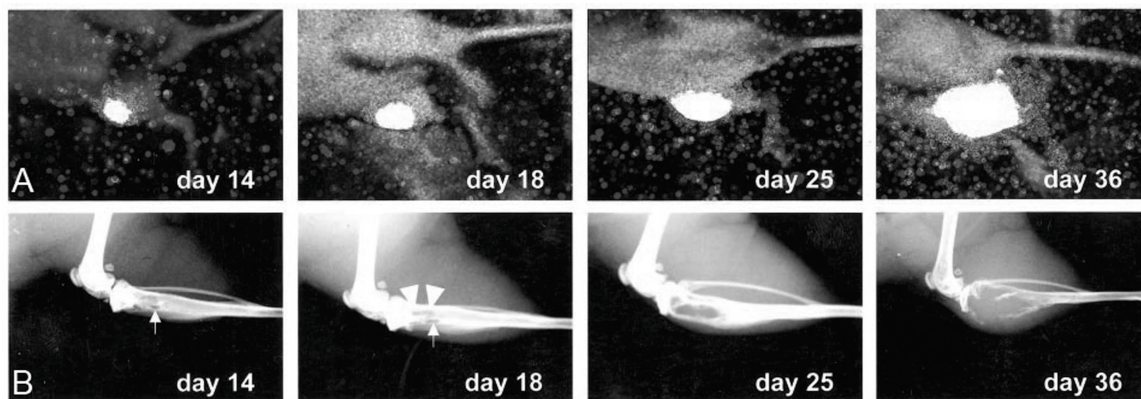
BLI and radiographic monitoring *in vivo* of the growth kinetics of the cancer cells implanted in the marrow cavity of the right tibia. Signals are displayed as pseudo-color image at the most sensitive 0- to 3-bit range. Small arrows at days 14 and 18 point at the cortical hole that resulted from surgical drilling. Arrowheads at day 18 highlight the initial area of osteolysis (Figure reproduced from [84]).
